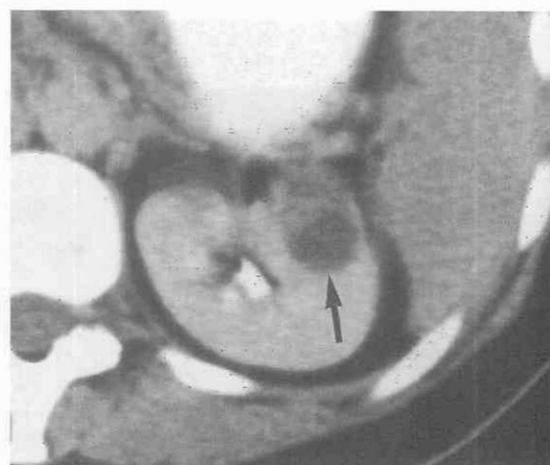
Cystic renal cell carcinoma; category IV lesion. Contrast-enhanced CT scan shows a cystic mass (arrow) with irregular and enhancing solid elements located anteriorly.
